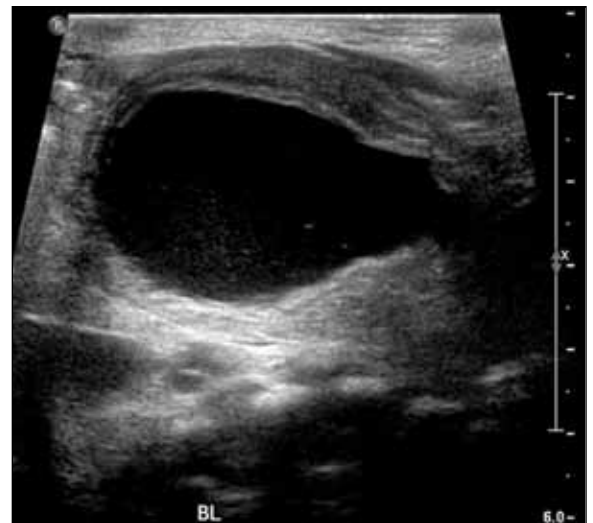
Severely trabeculated bladder and dilated posterior urethra seen on ultrasound.
